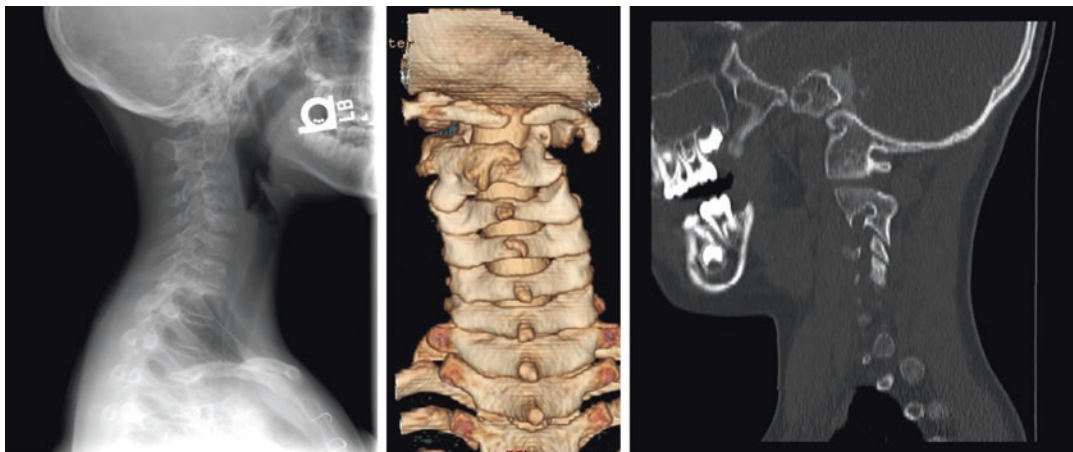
(a–c) Radiographs of a 10-year-old female with a fixed torticollis. (a) Lateral cervical spine radiograph shows occipitalization of C1 and a C2–C3 fusion. (b) CT with three-dimensional reconstruction showing rotatory
